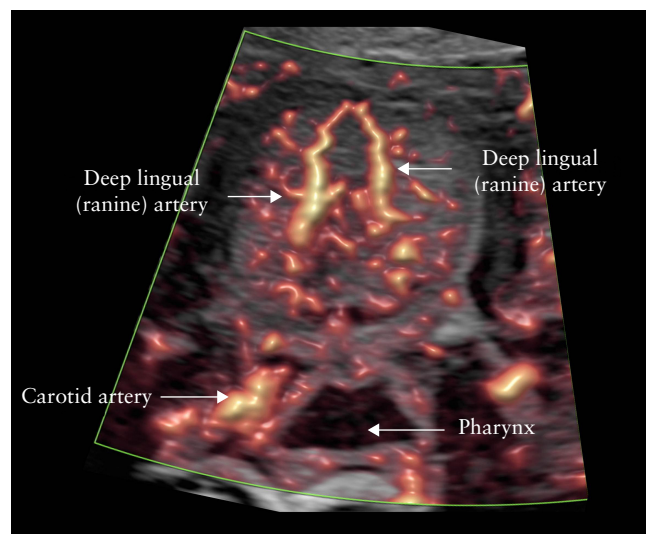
Cross-sectional Doppler ultrasound image of fetal tongue at 34 weeks of gestation, obtained using 2–9-MHz curvilinear probe and SlowflowHD™, showing deep lingual (ranine) arteries and their branches.
